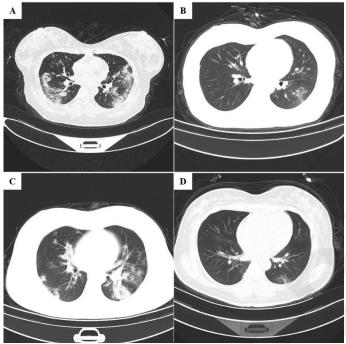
Chest CT scans of four COVID-19 patients.
